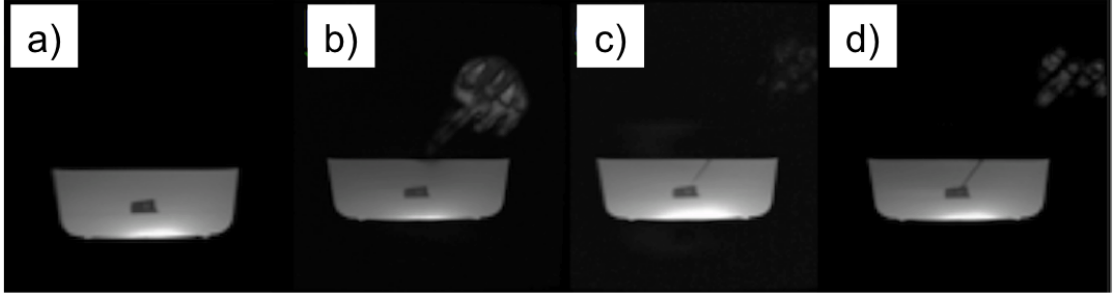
Simplified needle biopsy for a single oblique trajectory using the freehand approach and near real-time MRI guidance (FSPGR, TE/TR = 4.0 / 8.3 ms, Matrix = 256 x 256, FOV = 33 cm x 33 cm, FA = 60°, Slice thickness = 7 mm). The target lesion is shown in Figure (a). The needle entry point was identified (b) by finger pointing and the real-time scan plane was then updated to contain the skin entry and target point. The needle was then advanced towards the intended target (c) and the lesion punctured (d).
